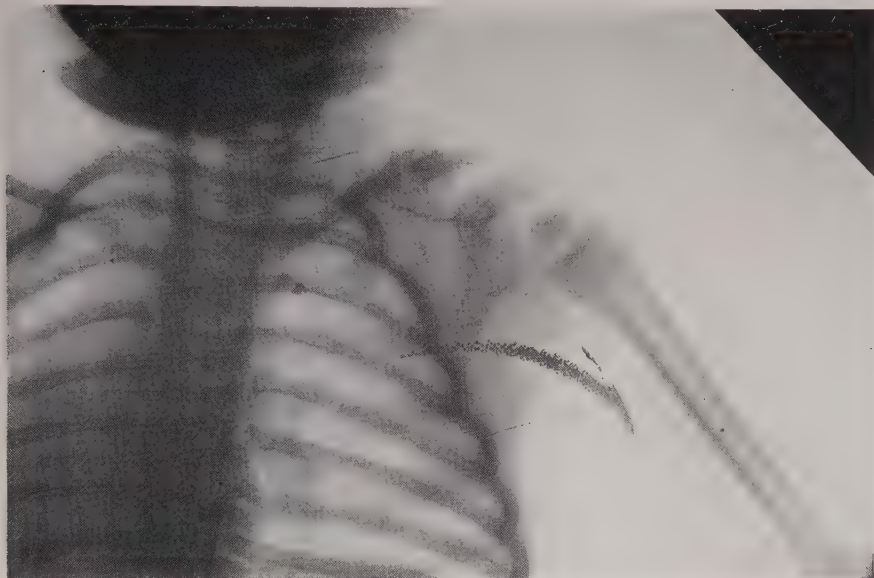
Fracture of the clavicle in an infant. This roentgenogram was made two weeks after injury. Note rapid callus formation.
